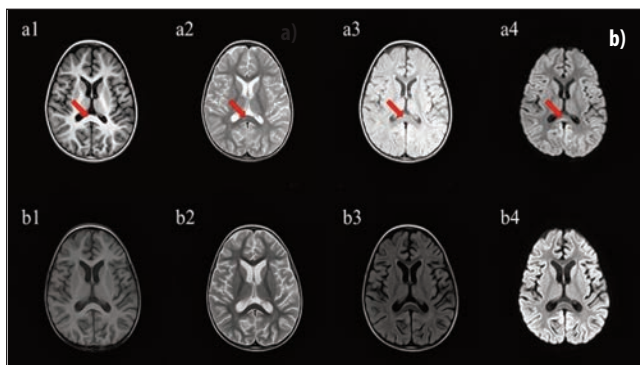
MRI results. a1-a4: T1-weighted image showed hypointensity; T2-weighted, fluid-attenuated inversion recovery and DWI imaging demonstrated hyperintensity in the splenium of the corpus callosum on day 4; b1-b4: T1-weighted image, T2-weighted image, fluid-attenuated inversion recovery and diffusion-weighted image demonstrated complete regression on day 12; Arrows indicate lesion on the splenium of the corpus callosum.
